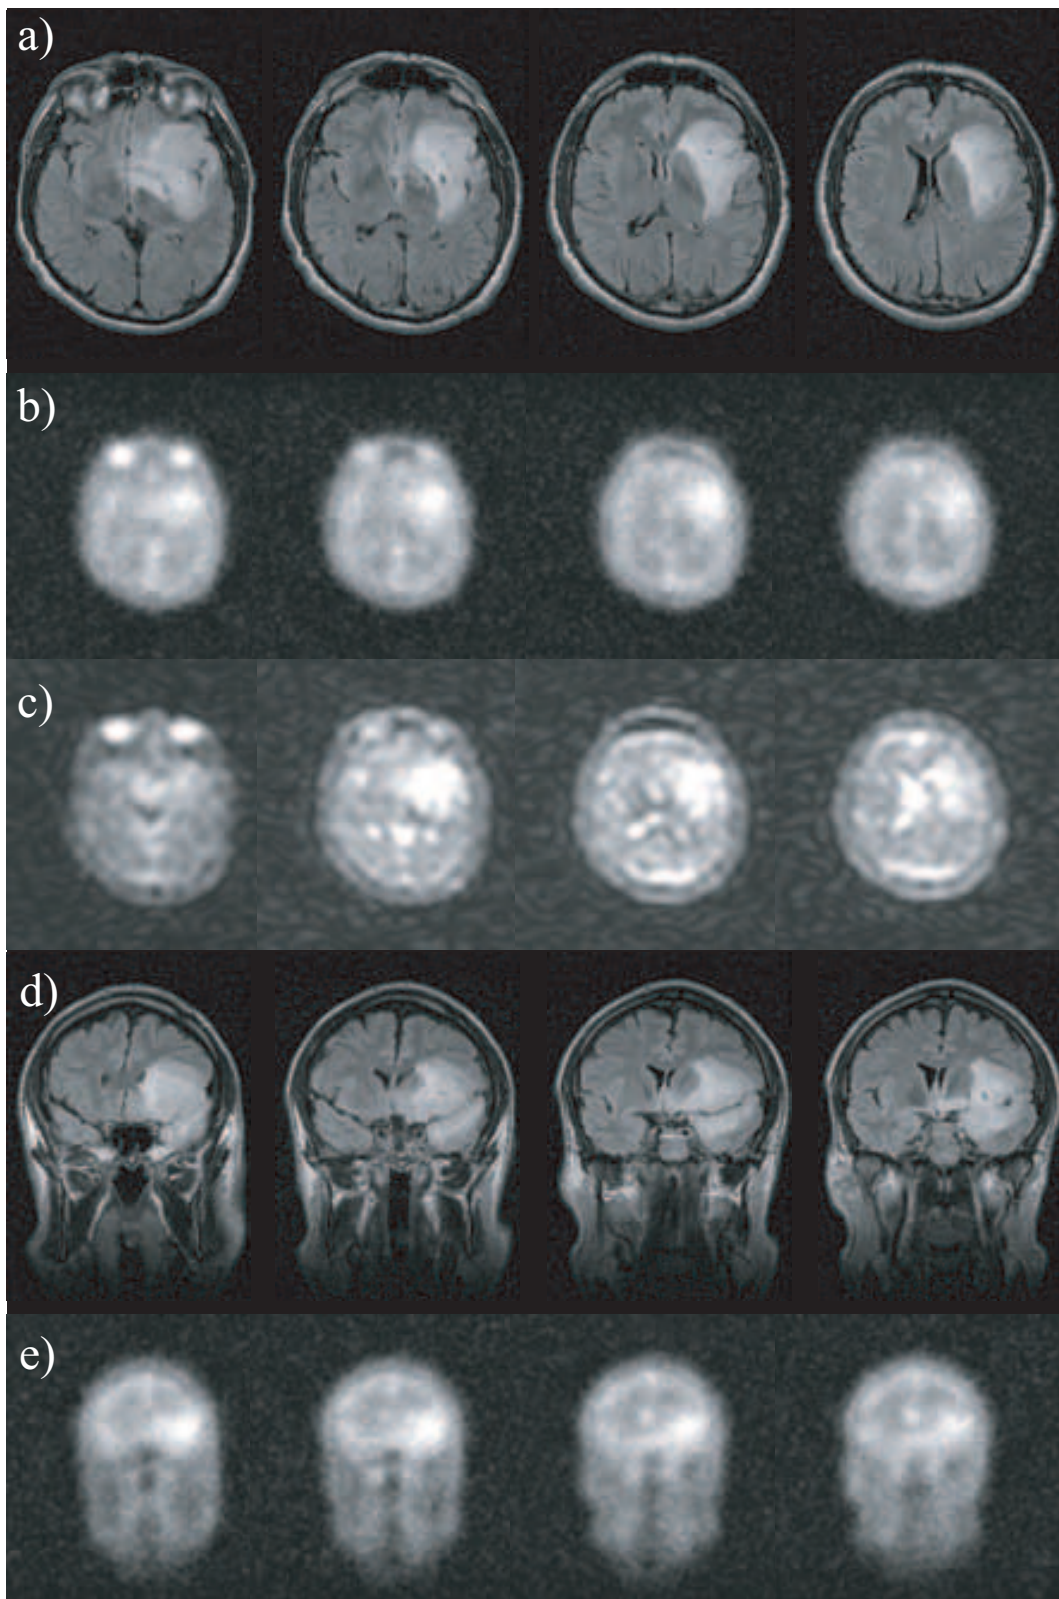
FLAIR images (a,d) and ^{23}Na radial (b,e) and FLASH (c) images of a brain tumour. The outline of the area with signal enhancement in the ^{23}Na images agrees with the shape of the tumour in the standard ^1H MR images.
